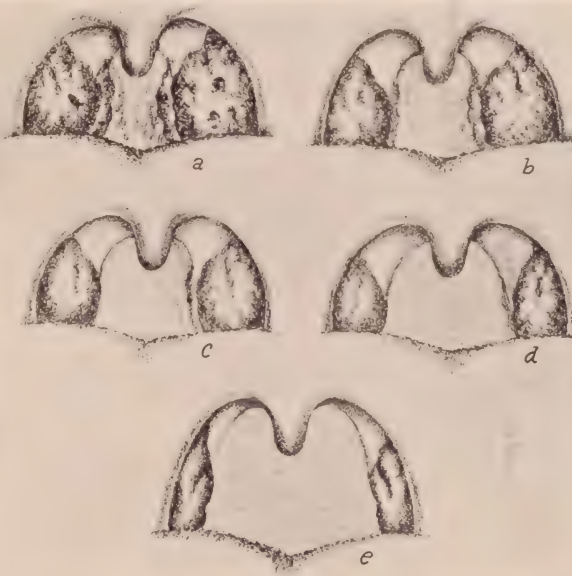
Figure II—a to e. (a) Tonsils before x-ray treatment; large, ragged, crypts contain pus. Large mass of lymphoid tissue behind posterior pillars. (b) Two weeks after treatment; tonsils reduced; surface smooth and clean. Mass behind pillars reduced. (c) Four weeks after treatment; tonsils markedly reduced pale and smooth; no exudate on deep pressure. (d) Eight weeks after treatment; small amount of exudate. (e) Six months after treatment; tonsils small, normal in appearance, no exudate on deep pressure. Lymphoid tissue behind pillars practically gone. Hemolytic streptococci disappeared from throat by second week after treatment.
